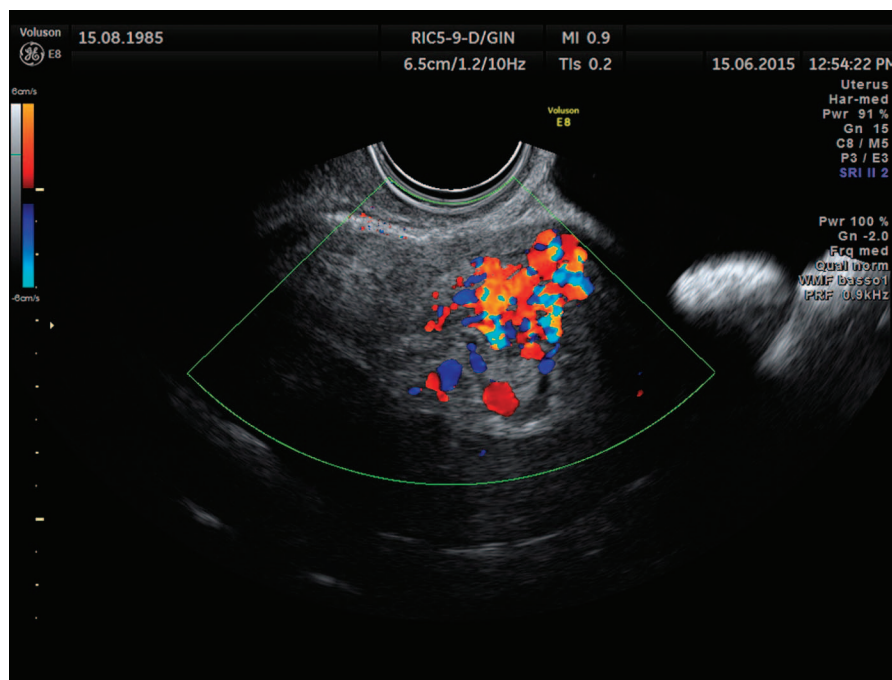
Visualization with transvaginal ultrasound with color Doppler AVM.
